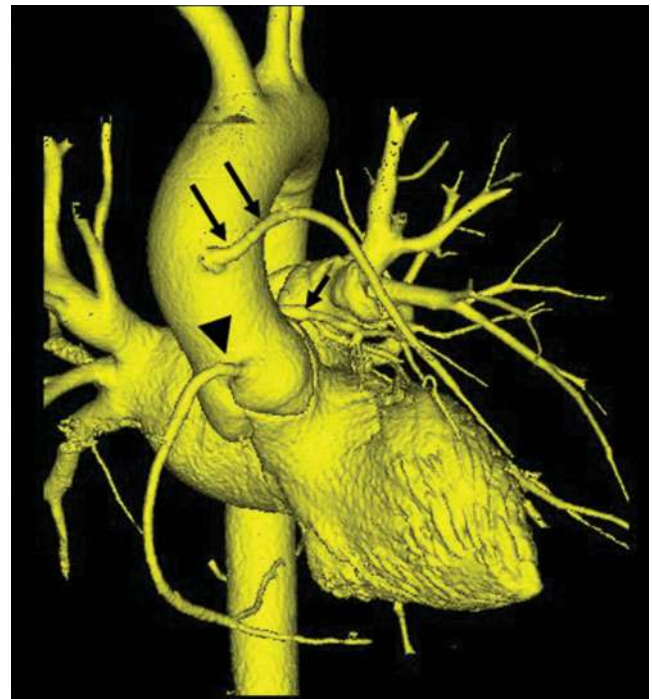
Coronary CT angiography follow-up of a coronary bypass graft. Three-dimensional surfaced shaded display shows a patent saphenous vein graft (long arrows) in a patient treated with a coronary artery bypass graft because of significant stenosis in the left coronary artery. The short arrow indicates the left coronary artery while the arrowhead indicates the right coronary artery.
